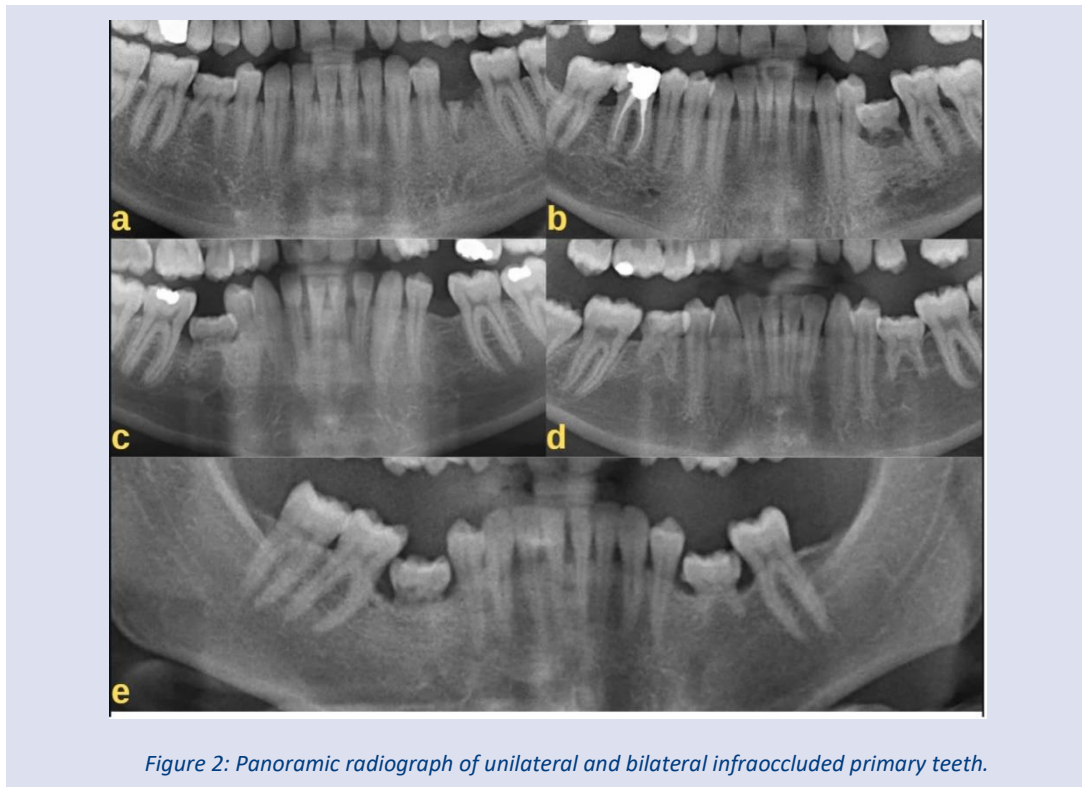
Panoramic radiograph of unilateral and bilateral infraoccluded primary teeth.
